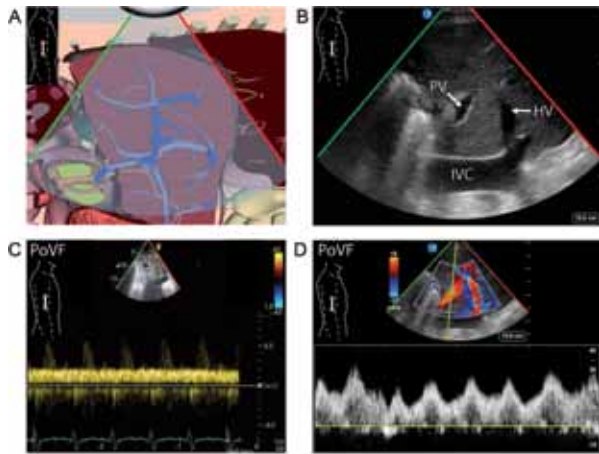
Portal venous flow. (A) Portal venous flow [PoVF] assessment from a posterior axillary line coronal view. (B) Using the same view, the inferior vena cava (IVC), portal vein (PV) and hepatic vein (HV) can be seen. Note the increased echogenicity of the PV wall. (C) Normal portal vein pulsed-wave Doppler has a monophasic signal indicating that blood is directed toward the transducer. Note the background pulsatile higher velocity of the hepatic artery, which is in the same direction. (D) Abnormal pulsatile portal flow with a pulsatility fraction of more than 50%. This finding indicates portal hypertension which, in right heart dysfunction, is associated with increased risk of complications.
